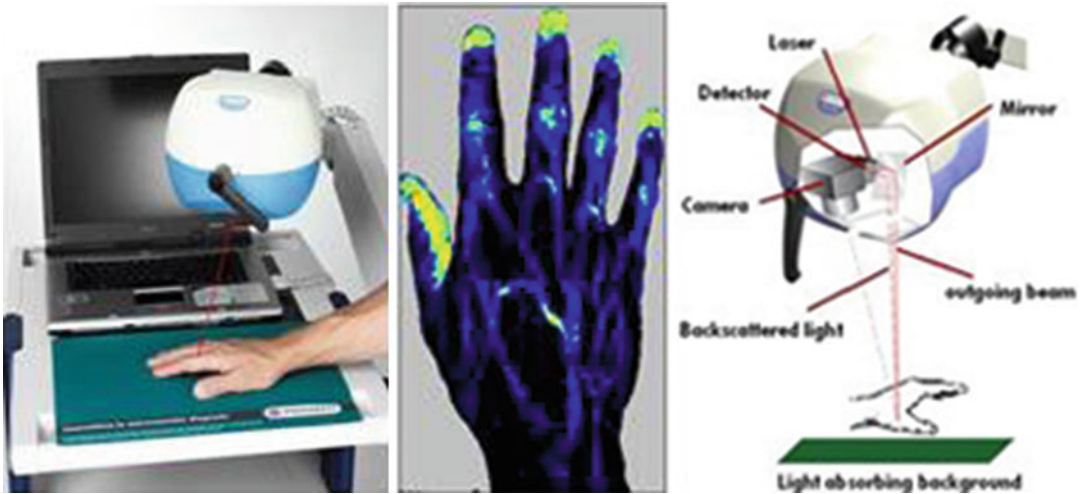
Laser Doppler perfusion imager. Intensity signal from a color-coded scale ranging from *dark blue* (lowest value) to *red* (highest value) (Courtesy of A. Moneta, Perimed Italia srl)
